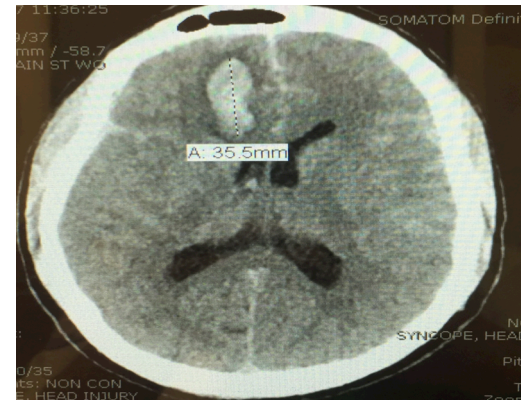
Initial CT Brain w/o contrast showing a parenchymal hematoma as well as a subarachnoid hemorrhage and minimal extra-axial blood. Minimal intra-ventricular blood also suspected in the third ventricle.
